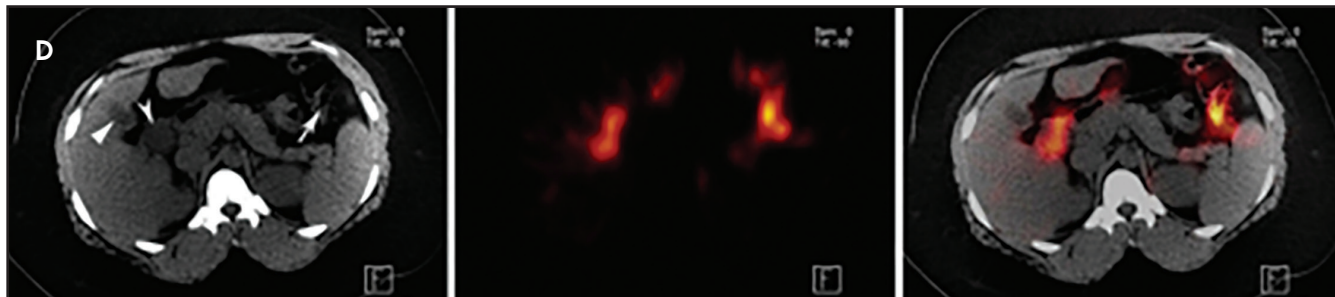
Images were obtained at 24 hrs on dedicated SPECT/CT equipment. Shown here are the axial low-dose CT (left), SPECT (center) and SPECT/CT fusion (right) images from the same level of the GB. CT localized the unremarkable appearing GB (flat-base arrowhead) and normal appearing right colon (concave-base arrowhead). The left colon is also seen (arrow). SPECT/CT fusion shows lack of tracer in the GB lumen, but an intense tracer activity in the colon. Notice that looking at the SPECT slice in isolation would not clarify anatomical location of activity or lack thereof, as clearly depicted on the SPECT/CT fusion image that permits precise GB localization.
